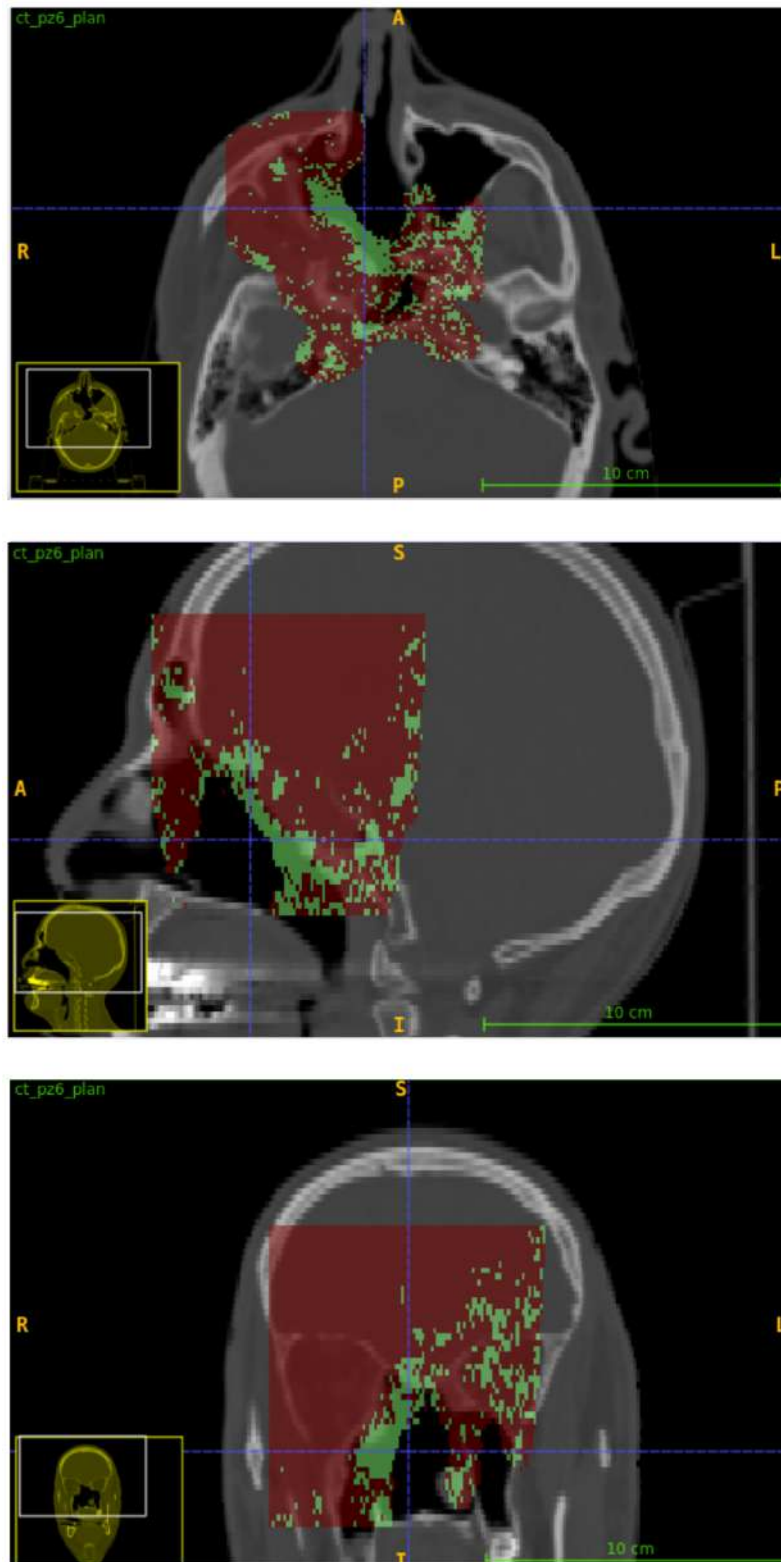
Pass rate map for  $DD = 20\%$ ,  $DTA = 2 \text{ mm}$ ,  $DTH = 0.5\%$  in axial, sagittal and coronal views (from top to bottom), overlaid on the planning CT.
